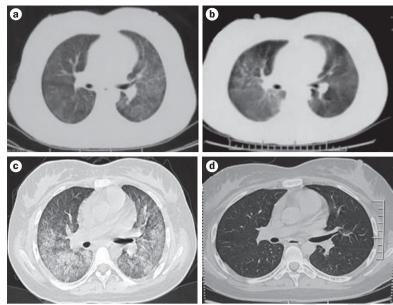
Chest HRCT scans before and after UC-MSCT. a | An initial HRCT scan of the chest shows bilateral, diffuse, alveolar infiltrates. b | Two weeks later, after the first course of treatment with pulsed methylprednisolone, a repeat HRCT scan of the chest shows progressive lung infiltrates. c | The second course of pulsed methylprednisolone 4 days later resulted in no improvements. d | Nine days after UC-MSCT, an HRCT scan of chest using a 3 mm collimation of the lung shows complete resolution of the lung infiltrates. Abbreviations: HRCT, high-resolution CT; UC-MSCT, umbilical cord mesenchymal stem cell transplantation.
